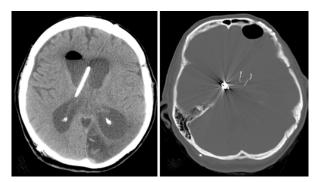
Case 3. Left: A CT scan showing ventriculomegaly, raising the question of shunt failure in a patient with subarachnoid hemorrhage who developed hydrocephalus and was treated with a shunt. Right: A CT scan showing a skull base defect and a leak at the site of the craniotomy.
